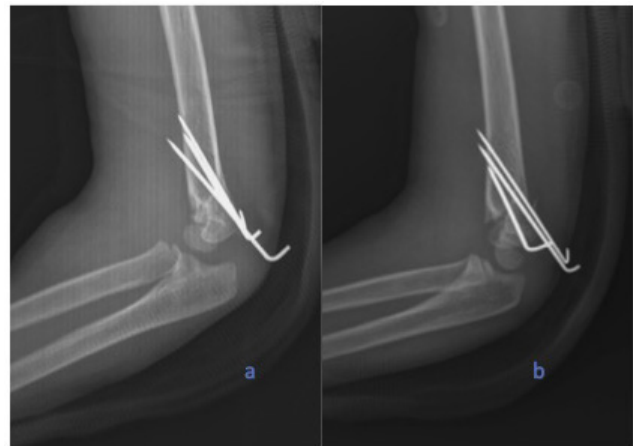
Early postoperative lateral X-ray, showing that the anterior humeral line is crossing the capitellum, 1-b. 3rd-week X-ray of this patient, distal fragment is displaced posteriorly. Although, both X-rays are not taken exactly from the same angles, it is obvious that the anterior humeral line is not crossing the capitellum.
